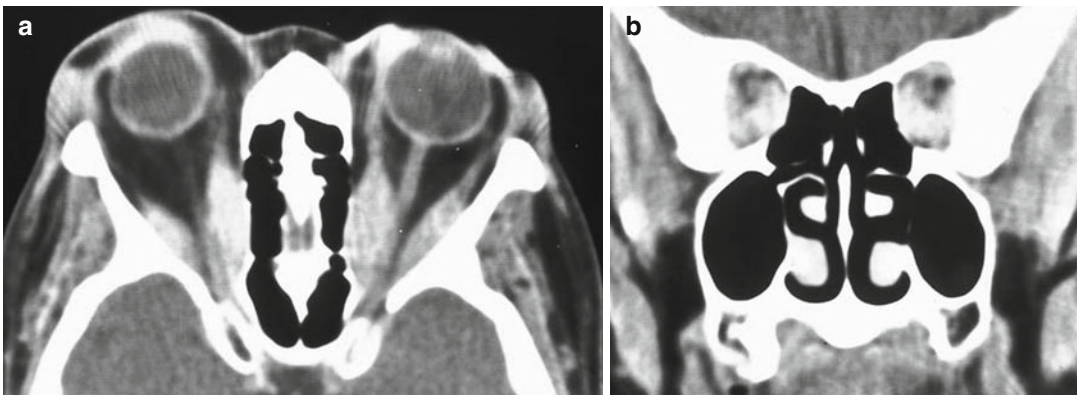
(a, b) Axial (a) and coronal (b) CT images show Apical crowding in a patient with thyroid eye disease and bilateral optic neuropathy
